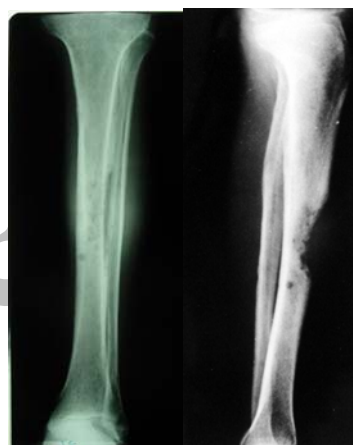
Case 2: The radiograph shows an osteolytic lesion arising in the diaphysis of the left tibia with extensive cortical disruption
